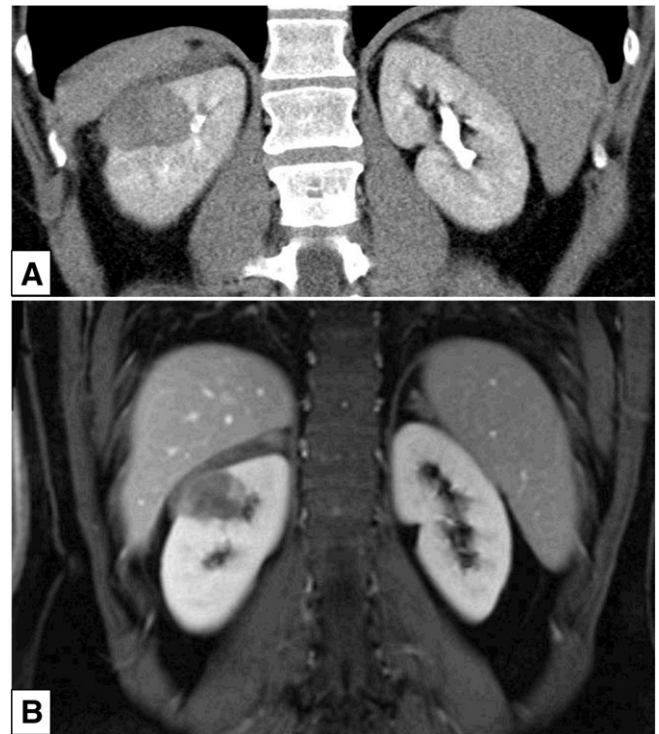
Case 2. Abdominal computed tomographic scan (A) and magnetic resonance tomogram (B) showed a mass with soft tissue density localized mainly into the right kidney and bulging through the renal capsule into perirenal fat.
